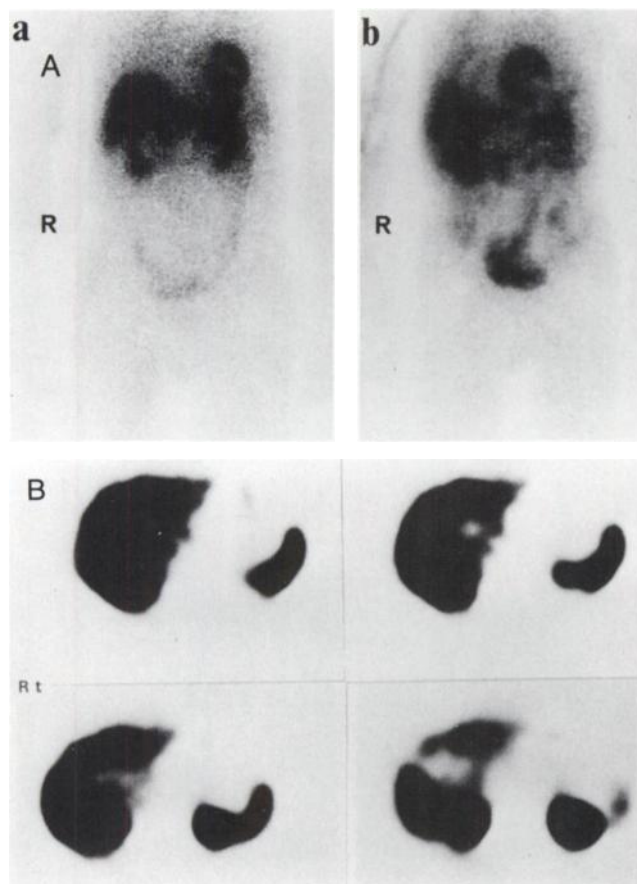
Thallium-201 planar (A-a) and SPECT (B) images of a control subject (a 57-yr-old man) after fasting. The planar image demonstrates diminished ^{201}Tl activity in the small intestine compared to the nonfasted control (A-b, a 53-yr-old male). SPECT did not show any abnormal ^{201}Tl uptake in the pancreatic bed.
